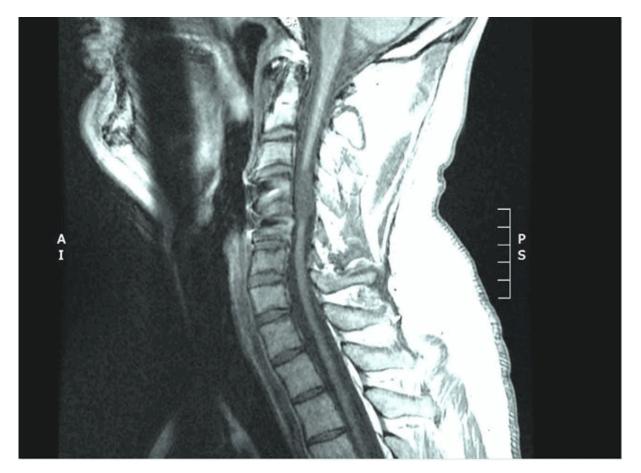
Base-line magnetic resonance image (MRI) of traumatised cervical spinal cord in a quadriplegic: Pre-cell transplantation T1-sagittal section at the transection site and 6-years after CSI and contemporary-treatment. SCNT cell-preparation implantation was performed via a direct posterior, midline neuro-surgical access approach and after debridement of the necrotic intra-thecal glial-tissue and debris. The biological cell-transplant-construct was inserted into the traumatic cord-gap by a neurosurgeon between the two-ends of the spinal-cord (arrows). Note irreversible, skeletal injury to adjacent cervical vertebra, vertebral discs and associated spinal cord-damage.
